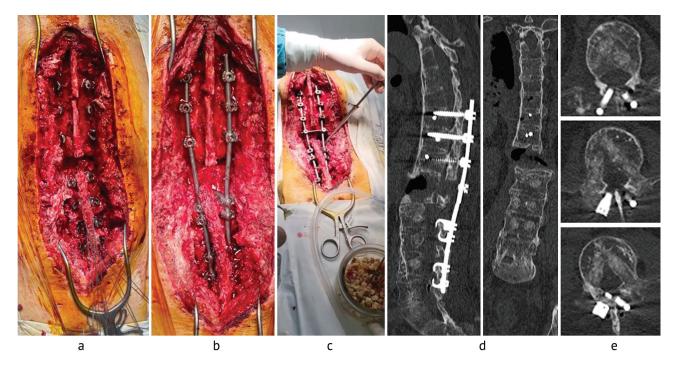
Intraoperative photoes and CT scans demonstrating stages of the second revision intervention including osteoplasty of post-screw defects: (a) a view of the surgical wound with hooks in place, the dorsal part of the vertebra is "suspended" by the original fixator; (b) a view of the surgical wound after rod placement and definitive fixation; (c) osteoplasty of post-screw defects using allogenic bone chips and orthobiological product thrombogel; (d) sagittal and frontal scans of the thoracic and lumbar spine; (e) L_2 , L_3 , L_4 vertebrae with zones of osteoplasty of post-screw defects
